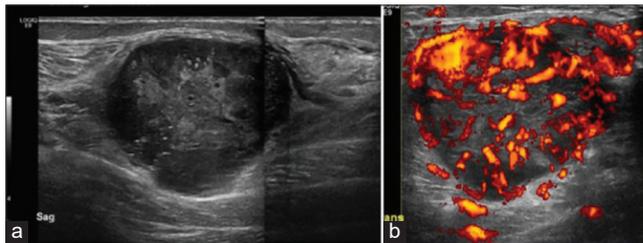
Extended view sagittal ultrasound image (a) of the lower leg demonstrating a large heterogeneous soft tissue lesion with marked hypervascularity on power Doppler imaging (b) subsequent biopsy confirmed a malignant fibrous tumor.
